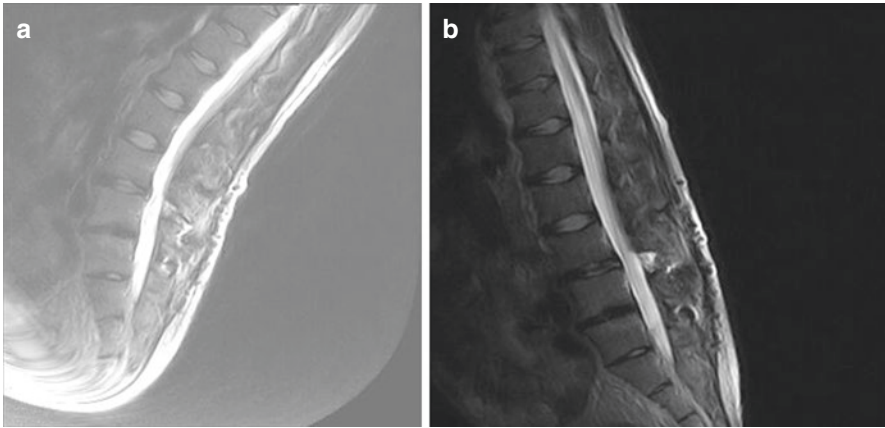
Small extruded disc at L4–L5 levels. (a) Patient in lumbosacral extension position MR imaging. (b) Patient in lumbosacral flexion position MR imaging
